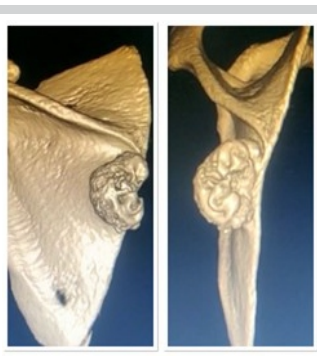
3 dimensional computed tomography images (reconstructed) showing large bony tumor arising from posteromedial aspect of the left scapula.
